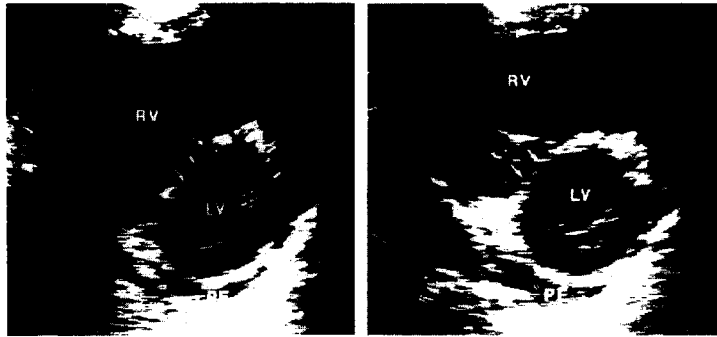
Parasternal short axis views of the right ventricle (RV) and left ventricle (LV) in diastole (left) and systole (right). There is diastolic and systolic bowing of the interventricular septum (arrows) into the left ventricle compatible with right ventricular volume and pressure overloads, respectively. The right ventricle is appreciably dilated and markedly hypokinetic, with little change in apparent right ventricular area from diastole to systole. PE=small pericardial effusion (from Come²⁵).
